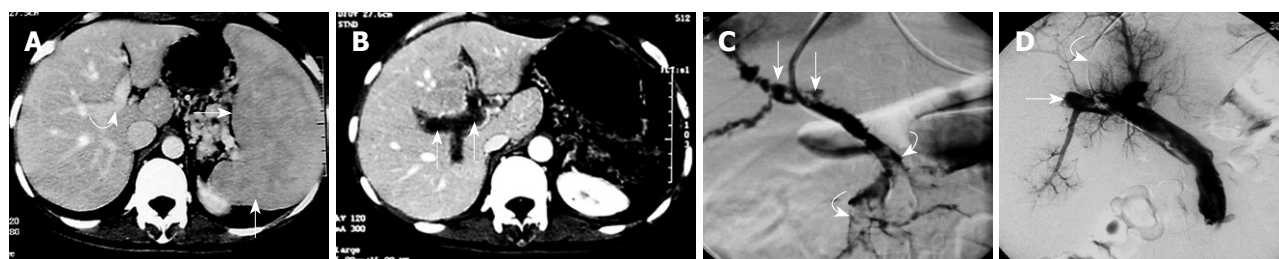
Case 3: A 38-year-old woman with abdominal pain, nausea, distension, and vomiting for 3 d. She had undergone splenectomy 2 wk previously. A: Selected axial image from before open splenectomy contrast-enhanced CT shows splenomegaly (arrows) and patent portal vein (curved arrow); B: Selected axial image from admission contrast-enhanced CT, on postoperative day 14, shows extensive thrombus within the PV (arrows); C: Pre-treatment direct venography via transjugular approach access to the portal vein showing extensive PV (arrows) and SMV (curved arrows) thrombosis, without collateral drainage; D: Follow-up direct portal venography via the infusion catheter (curved arrow), obtained 5 d after the catheter infusion of thrombolytics, shows patent PV and SMV with residual thrombosis within the intrahepatic portal venous branches (arrow).
